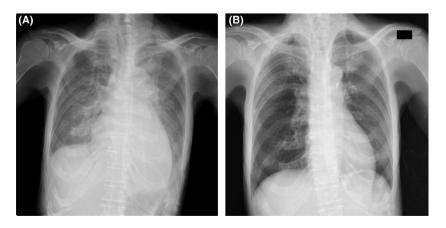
Chest radiograph on admission (A) and on the 47th day of hospitalization (B) at approximately 3 weeks after steroid therapy. Cardiomegaly (CTR; cardiothoracic ration of 60%) and pleural effusion were observed on admission. Effusion disappeared and the CTR had decreased during treatment.
